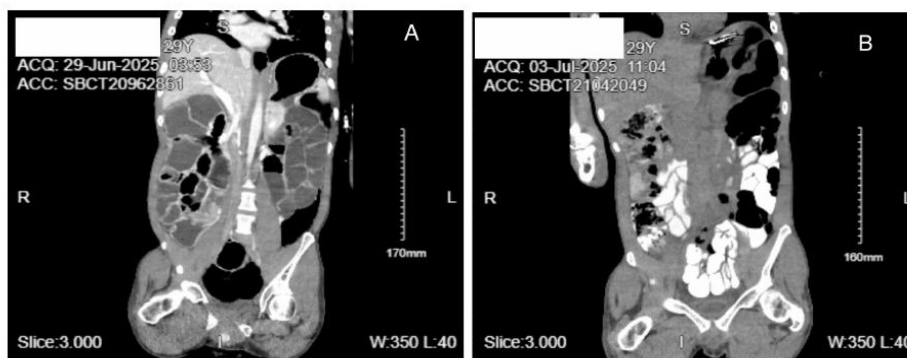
(A) CT A/P on admission. (B) Repeat CT A/P
